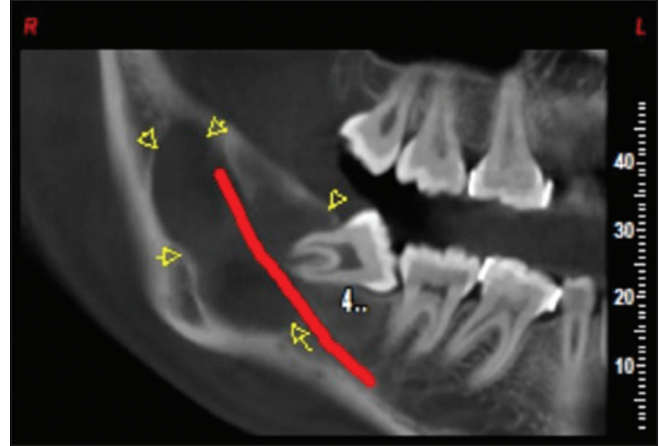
The CBCT shows a well-defined, unilocular mildly expansile osteolytic hypodense lesion with scalloped borders distal to 48 extending into ramus, with thinning of lingual plate distal to 48
